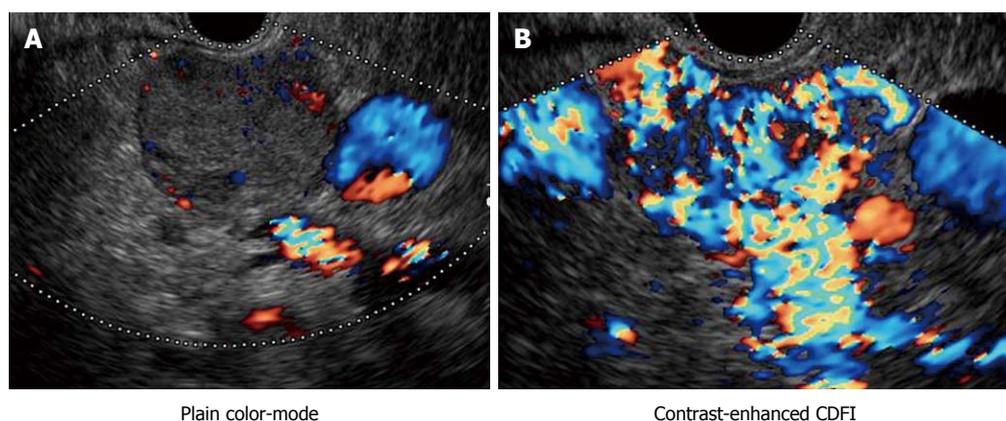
Endocrine tumor of the pancreas. A: Plain color (non-enhanced color) Doppler endoscopic ultrasonography (EUS) only showed few color signals inside the clearly delineated iso-echoic tumor; B: In contrast, there were abundant color signals inside the tumor, indicating it was hypervascular. B-mode image combined with contrast-enhanced EUS images provided an important clue for the diagnosis of pancreatic endocrine tumors. Levovist® was used in this case.
